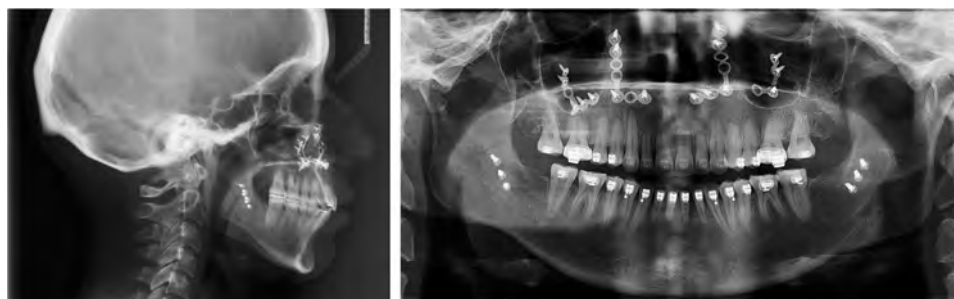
Final cephalometric (3 months after debond) and panoramic radiographs (1 week before debonding).
